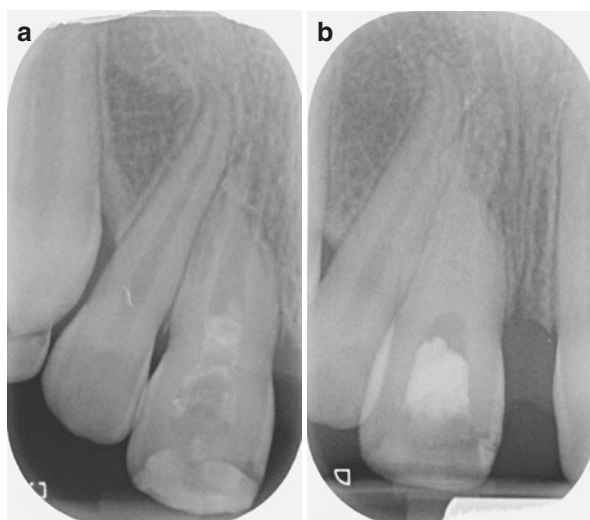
Enamel-dentine fracture and avulsion injury of the UR1 in a 9-year-old. Periapical assessment of the UR1 which has undergone progressive external root resorption following reimplantation (a) and at 12-month follow-up (b)
